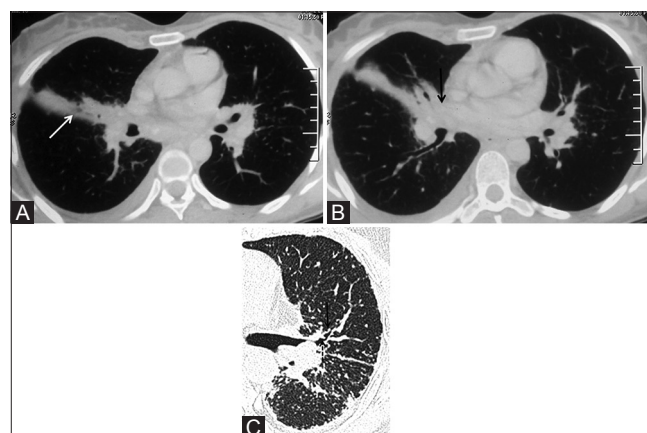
(A-C): Airway involvement in sarcoidosis. (A) Axial CT lung window image in a known case of sarcoidosis shows segmental atelectasis in right middle lobe (white arrow) likely due to compression on right middle lobe bronchus by right hilar lymphadenopathy (B) (black arrow). (C) Magnified axial high resolution computed tomography (HRCT) image in a different patient with pulmonary parenchymal sarcoidosis shows irregularity due to nodules along the walls of left upper lobe bronchus (thin arrow) and an endobronchial rounded nodule (dashed arrow) suggesting bronchial involvement by sarcoid granulomas. Rest of the lung shows subpleural and fissural micronodules
